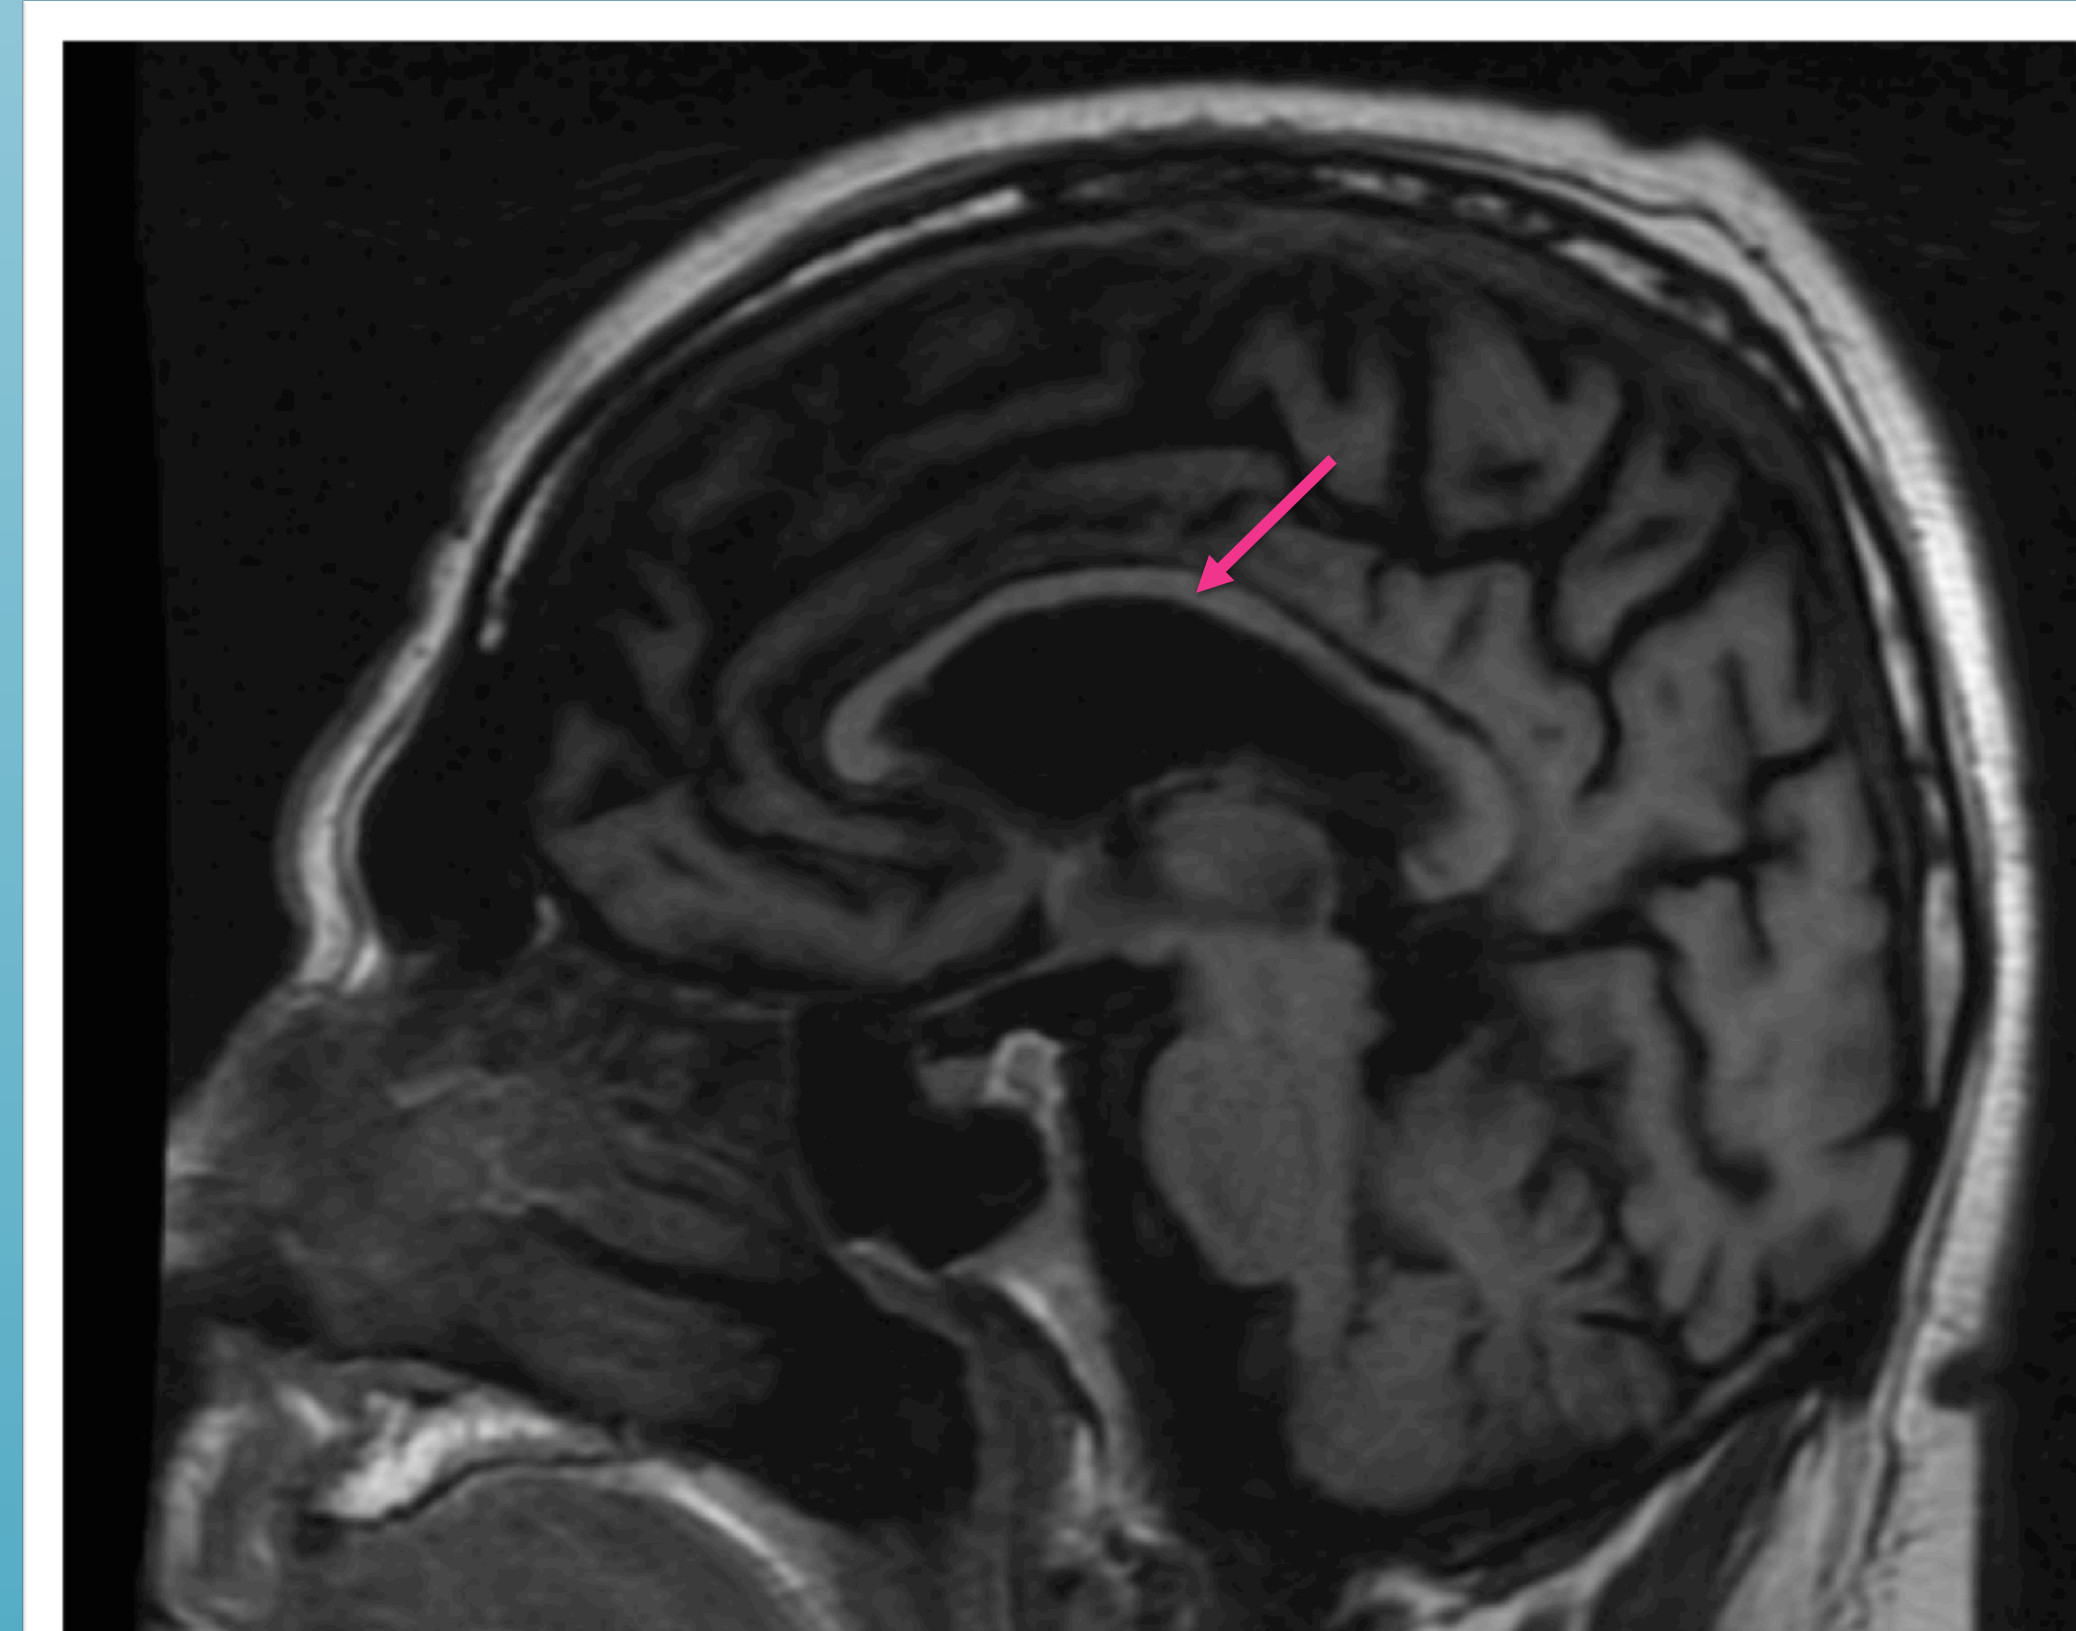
MRI brain without contrast, sagittal view of T1 sequence showing marked thinning of the corpus callosum.
